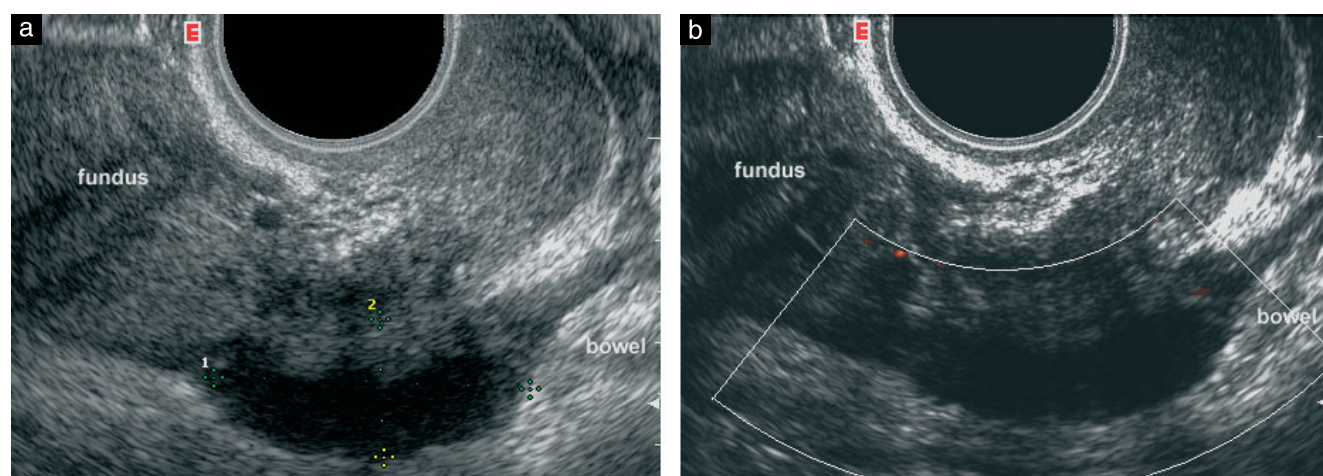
Sagittal transvaginal ultrasound images of the posterior compartment of the pelvis, including the pouch of Douglas. (a) Gray-scale image: a solid hypoechoic nodule with blurred margins and a hyperechoic rim (calipers) suggestive of the presence of deep infiltrating endometriosis is seen at the level of the anterior wall of the rectum. (b) Power Doppler reveals the absence of blood vessels inside the nodule.
